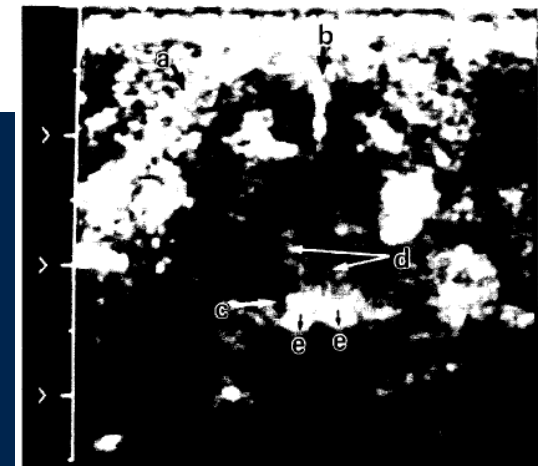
Ultrasound image of normal larynx. a — thyroid cartilage, b — anterior commissure, c — ventricle, d — true vocal cord, e — arytenoids.
